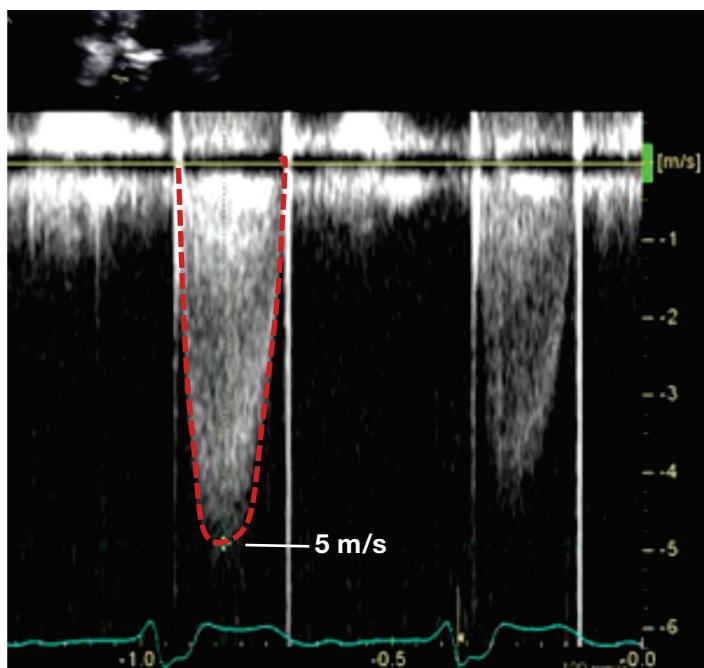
Transthoracic Doppler study demonstrates a high pressure gradient (100 mmHg) across the prosthetic aortic valve.
